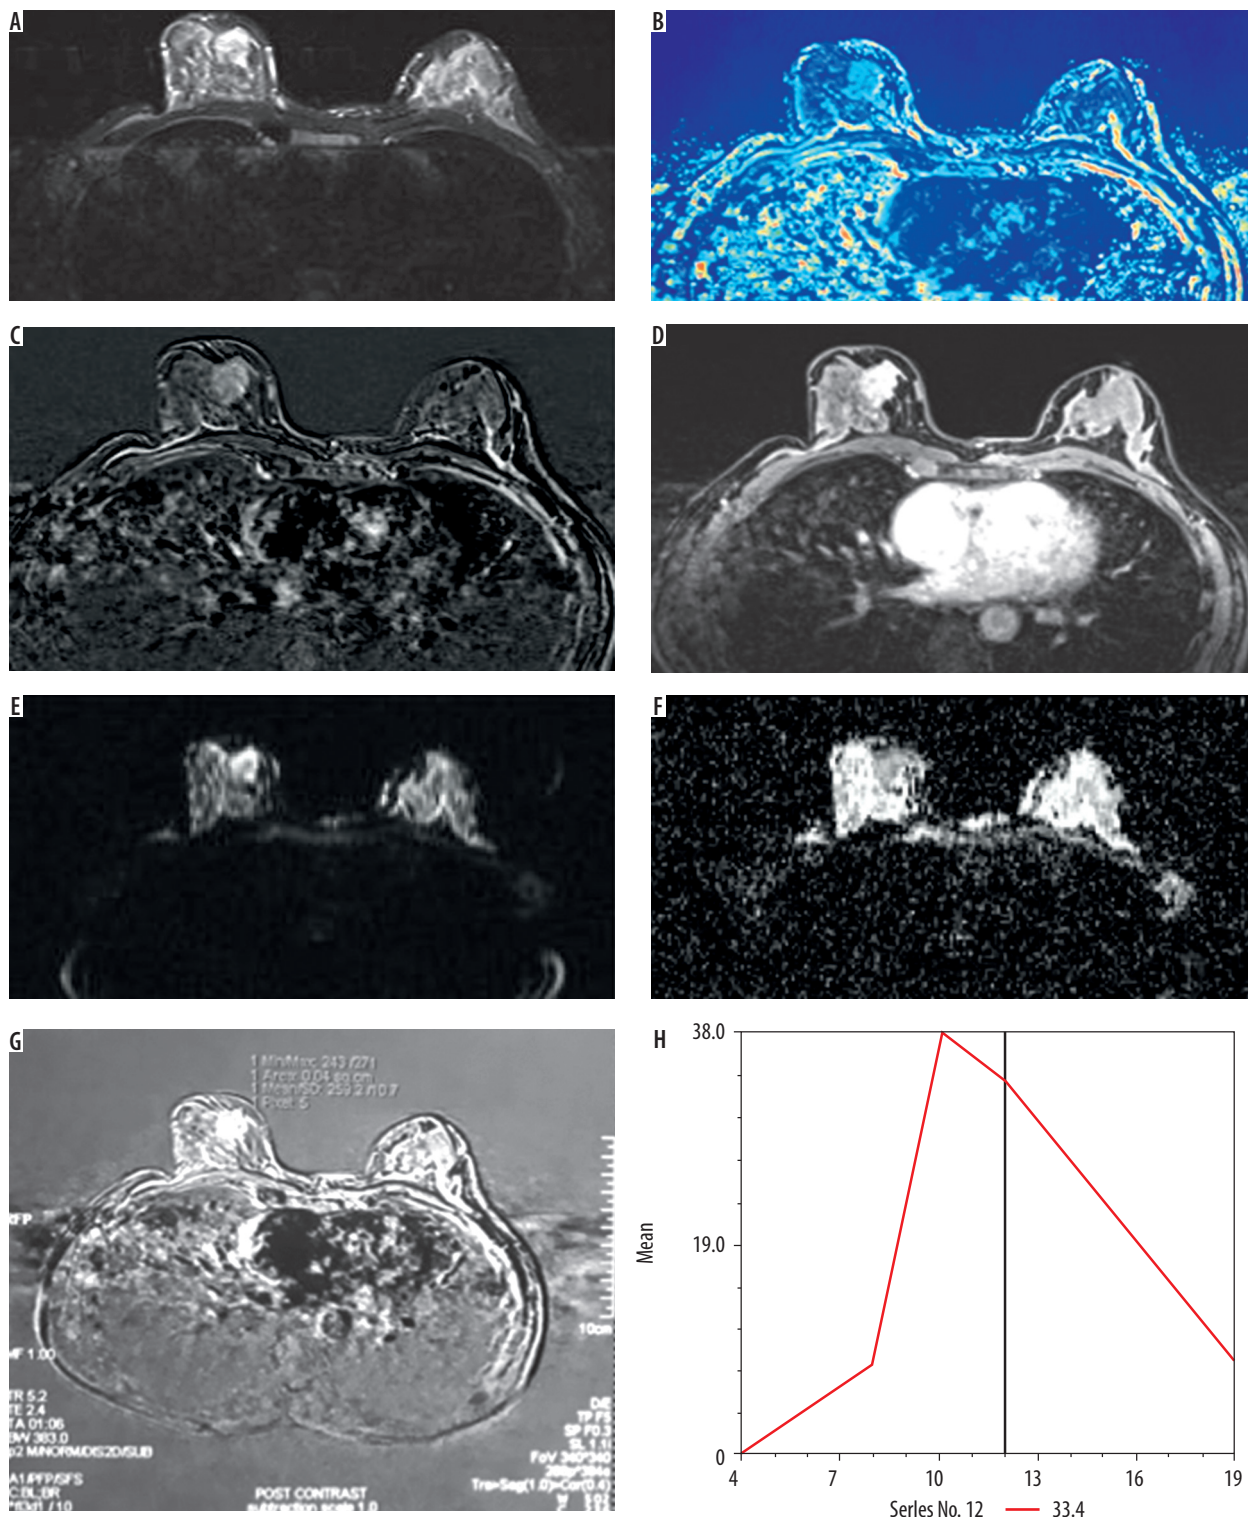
Magnetic resonance breast imaging in a case of invasive lobular carcinoma in a 52-year-old woman. A) Axial STIR image of the breast showing a well-defined irregular mildly hyperintense mass seen in the right breast with lobulated margins. B) Wash-in colour showing early enhancement of the mass (C) and post contrast (D). Axial fat sat T1WI image showing early enhancement of the mass. E) Axial diffusion weighted imaging (DWI) showing hyperintense signals in the mass with f: corresponding low apparent diffusion coefficient value (restriction on DWI). G-H) Time signal intensity curve of the mass showed type III kinetic curve (early washout)
